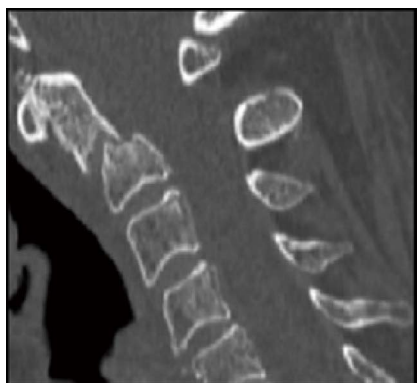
Interval computed tomography-scan 6 mo after the index injury. No healing is demonstrated, sclerotic bone margins are demonstrated at the fracture fragments.
